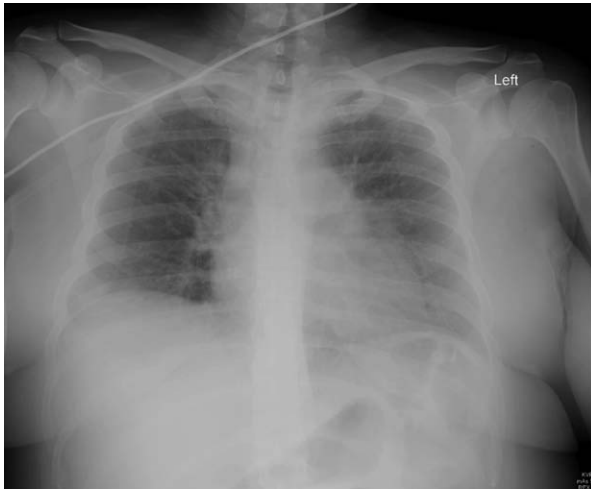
Chest radiograph on the day of discharge.
